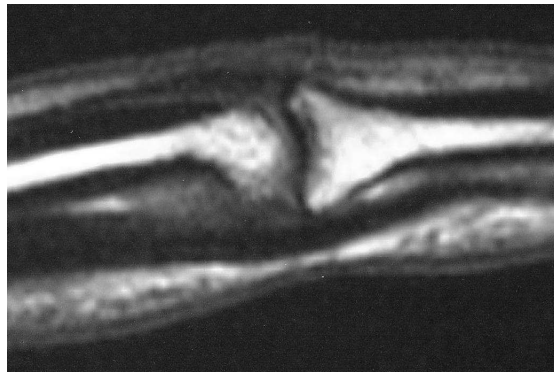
MRI of the human PIP joint with the interior side on the top. The synovial cavity between the two bones that is filled with synovial fluid is clearly visible in the center of the image.
